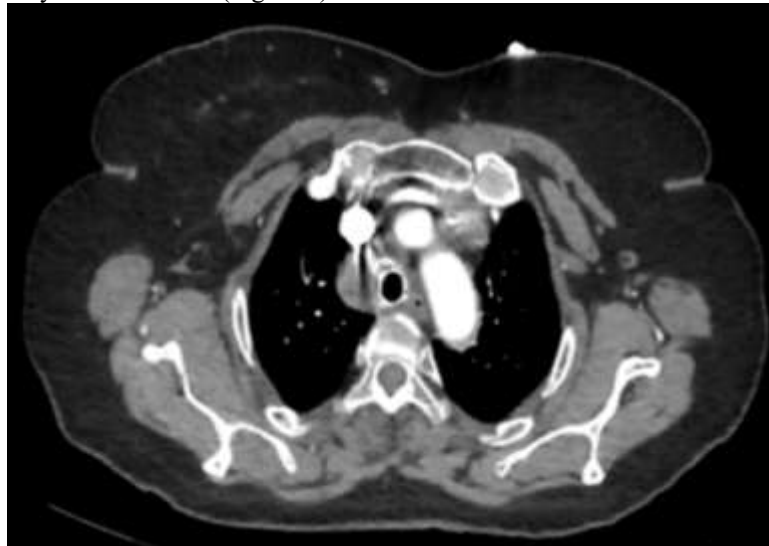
CT Appearance After Placement of the Tracheal Stent.
